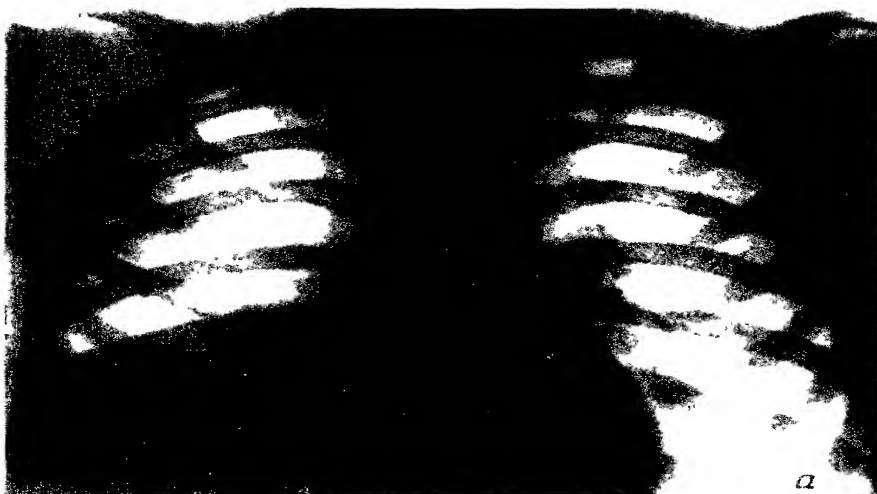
Lung X-rays of case with pleurisy with effusion in the right lung
